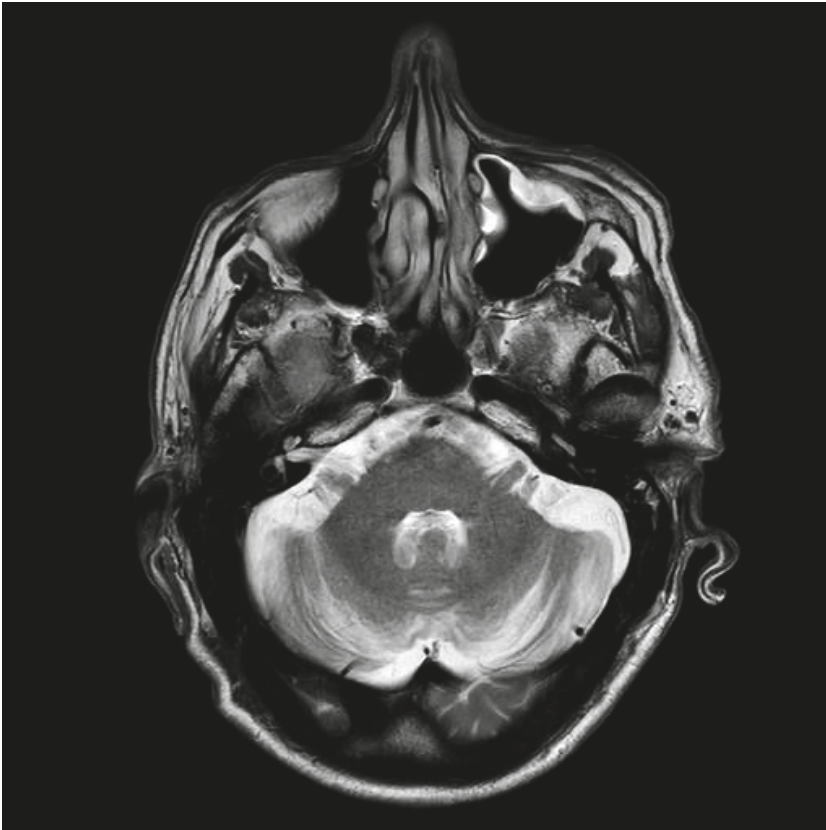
Brain MRI scan conducted on the same patient, as in Figure 3. The scan was conducted in 2018 and at that point showed evidence of cerebellar atrophy that apparently developed over an interval of 21 years. The patient now displays clinical evidence of cerebellar ataxia.
